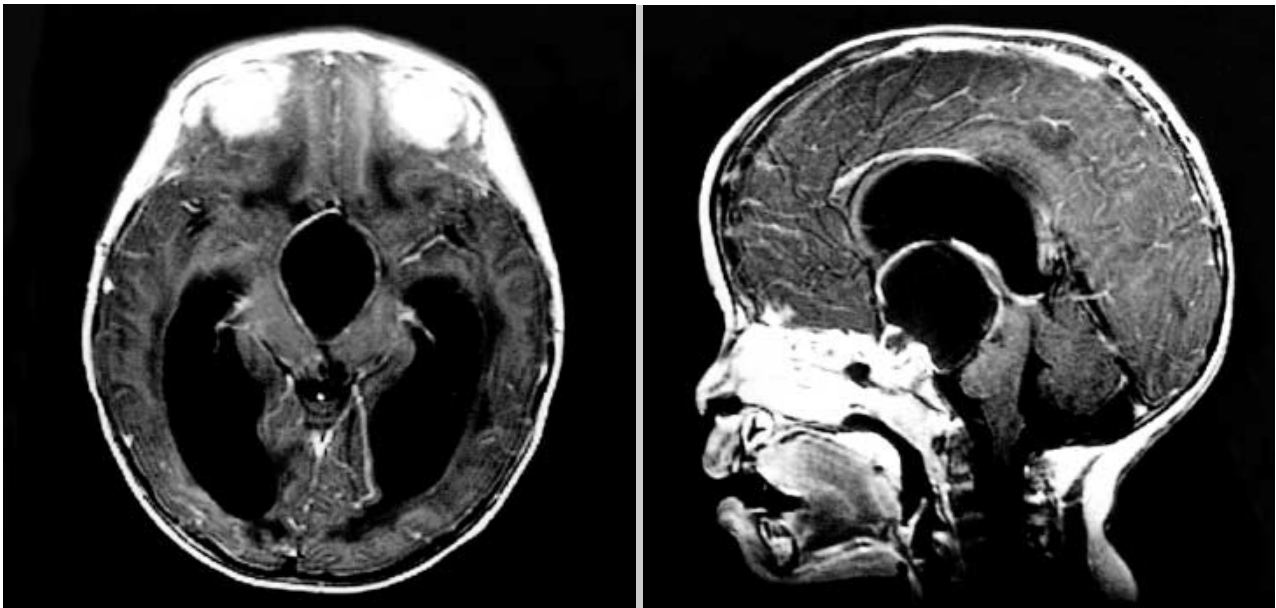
Preoperative brain MRI in a 3-yr-old boy who presented with right hemiparesis (Patient No. 10).
